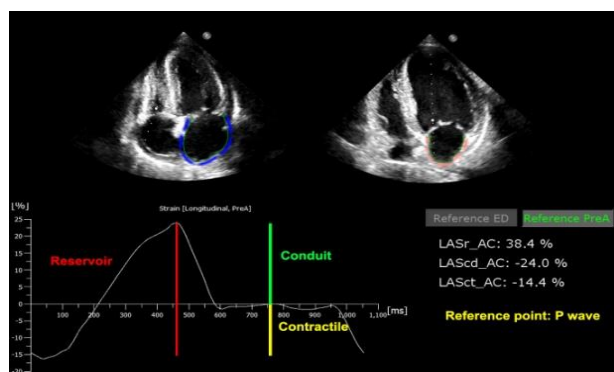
Parameters of LA strain on speckle-tracking echocardiography.
